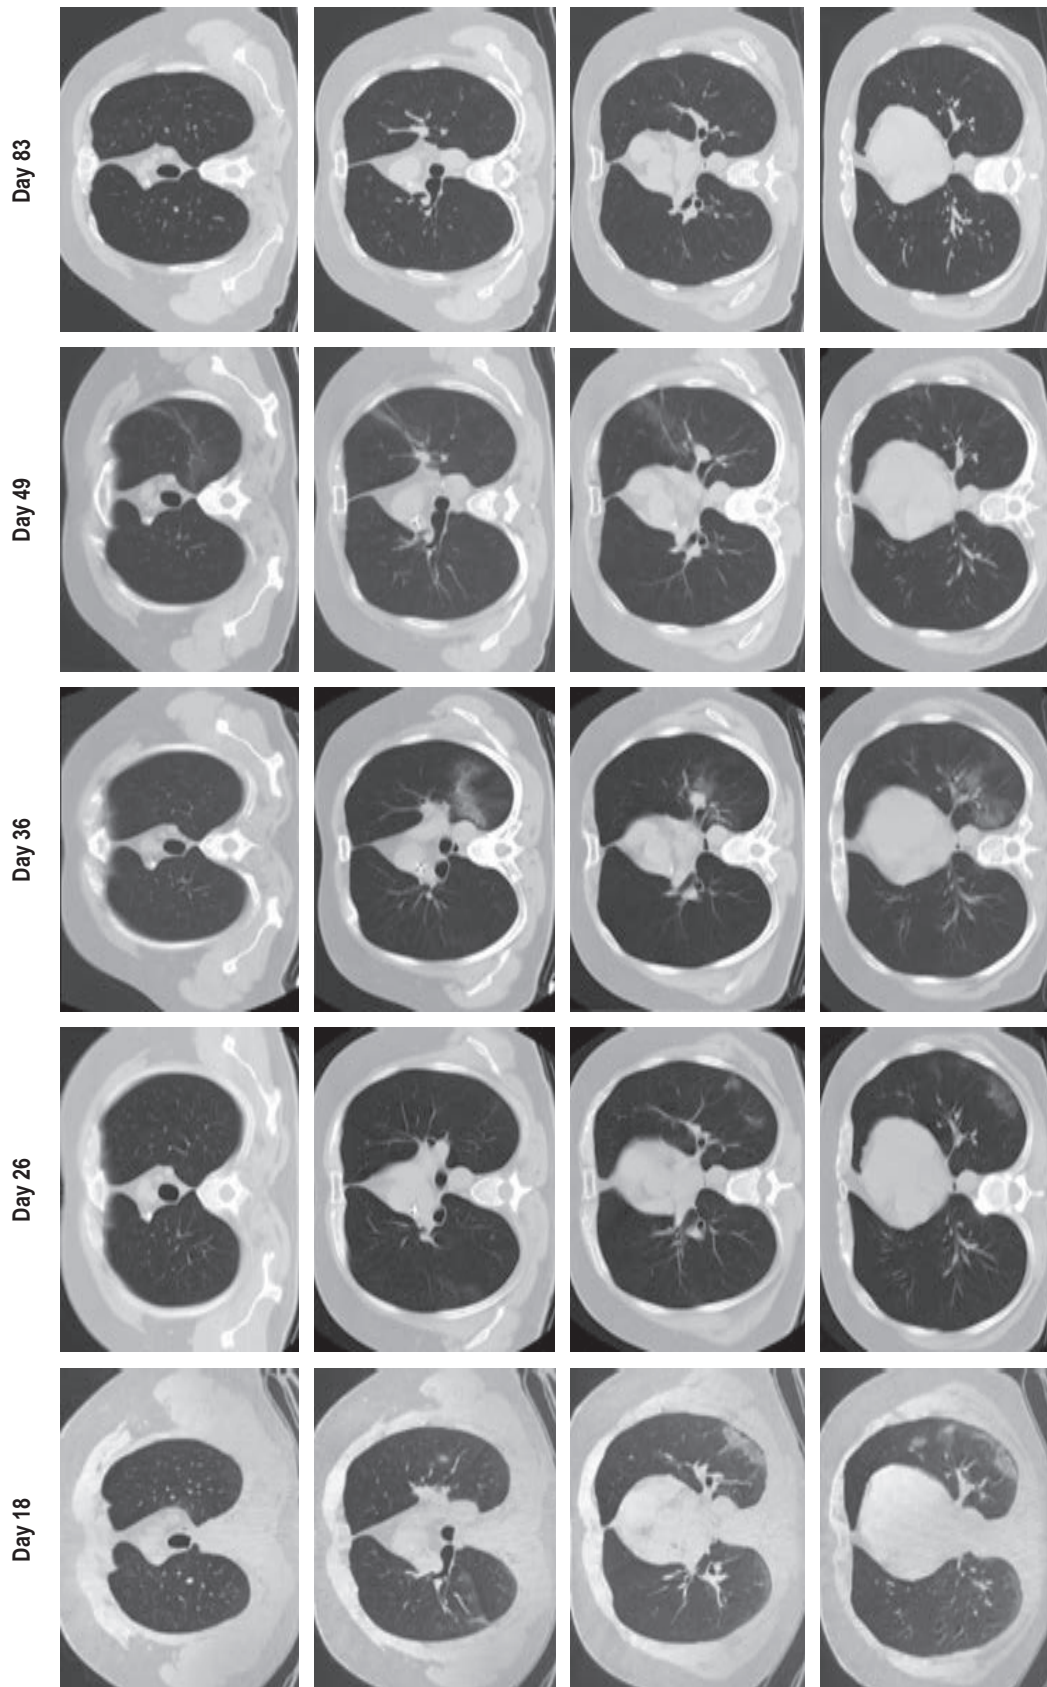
Transition of the pulmonary lesions due to COVID-19 pneumonia in the case presented on computed tomography. The migratory behavior of the COVID-19 lung lesions is evident. The evolution is shown as the number of days after the initial symptoms.
